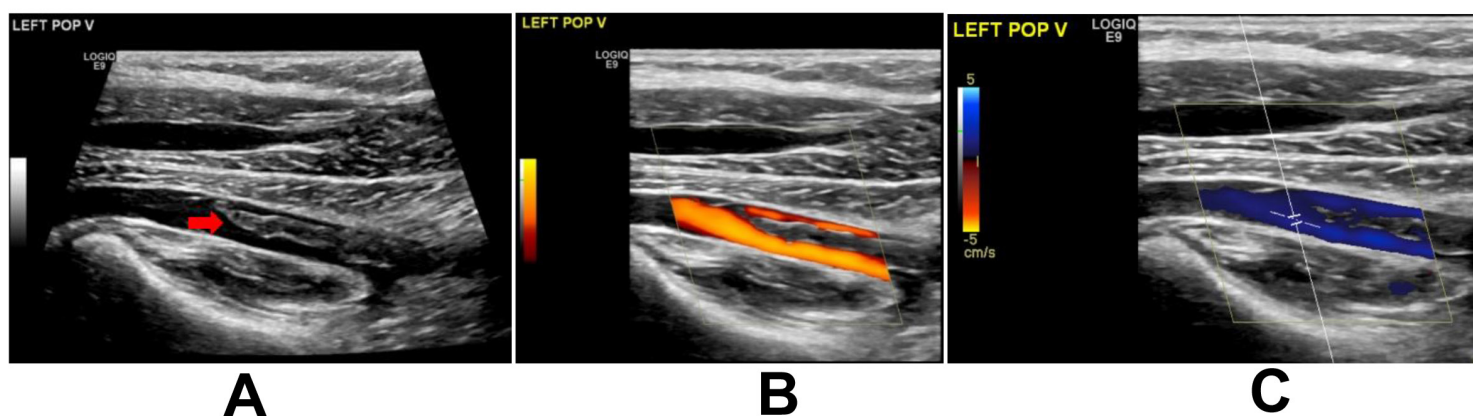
Ultrasound venous Doppler Scan of the left lower limb showing acute nonobstructive thrombus in the left popliteal vein (red arrow).
